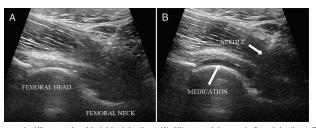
Ultrasound-guided hip injection. (A) Ultrasound image before injection; (B) image after injection. The anechoic area indicated by the white arrow is the injected medication.
